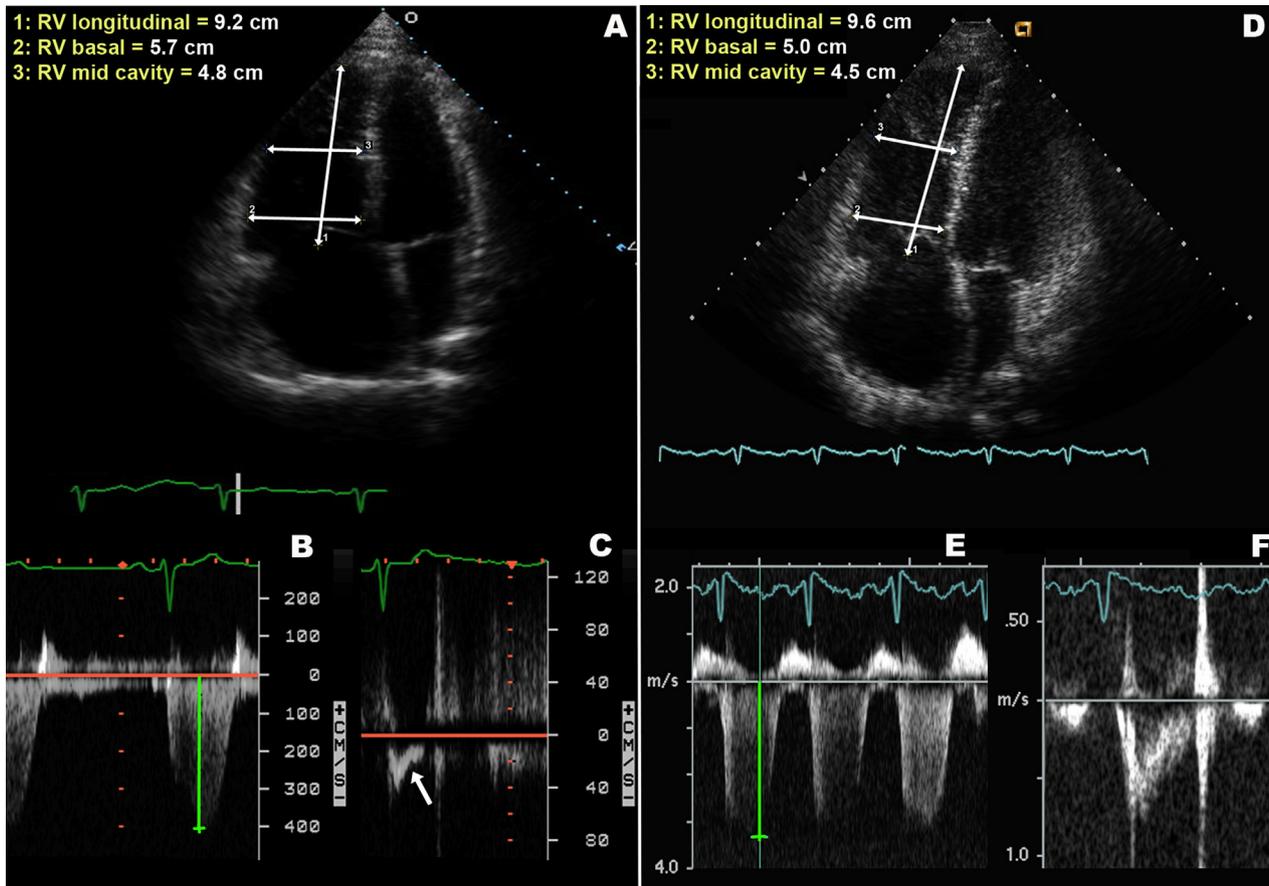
Echocardiograms at baseline and after 1 year of treatment with prostacyclin analogue. RV dimensions (A), tricuspid regurgitant jet (B), and RV outflow tract flow (C) of the baseline echocardiogram. RV basal and middle cavity and longitudinal dimensions were 5.7, 4.8, and 9.2 cm, respectively. The tricuspid regurgitation velocity was 4.1 m/sec. The RV outflow tract flow had a mid-systolic notch (*arrow*), and the velocity-time integral was 7.4 cm. RV dimensions (D), tricuspid regurgitant jet (E), and RV outflow tract flow (F) of the echocardiogram after 1 year of treatment. RV basal and middle cavity and longitudinal dimensions were 5, 4.5, and 9.6 cm, respectively. The tricuspid regurgitation velocity was 3.3 m/sec. The RV outflow tract flow had no notch, and the velocity-time integral was 13.1 cm.
